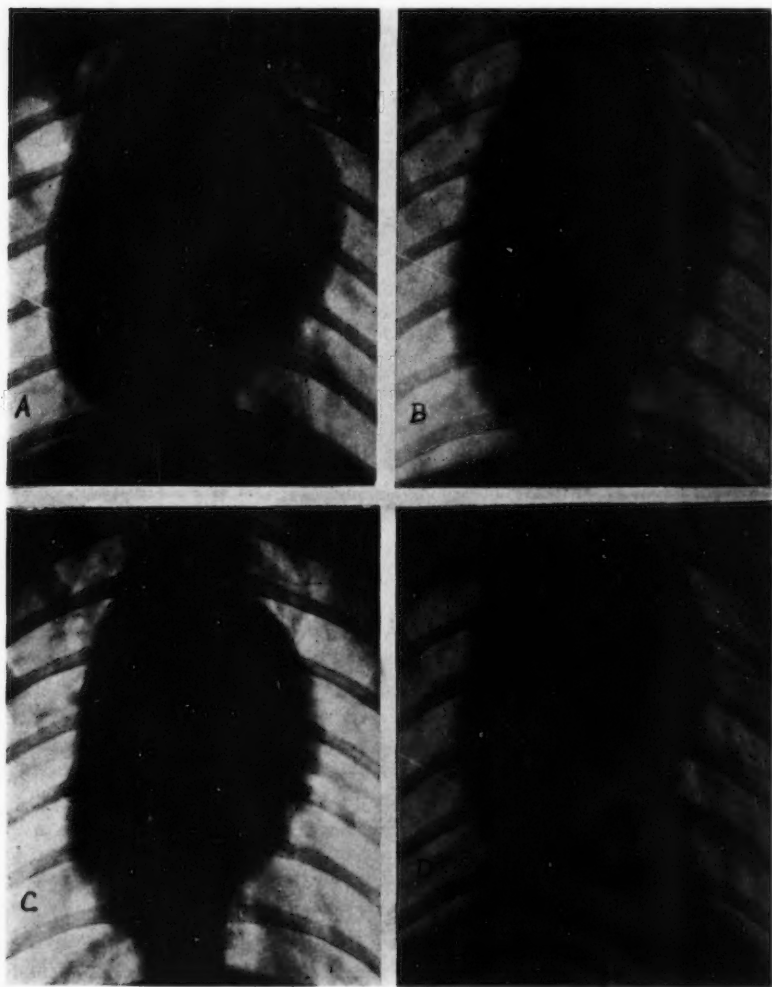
X-ray silhouettes from experiment H 60. Ether anesthesia. Rates varied by stimulation of right vagus. A, 72 beats per minute. Area = 43.4 sq. cm. B, 108 beats and area of 41.4 sq. cm. C, rate of 123 and area of 36.9 sq. cm. D, rate of 171 and area of 34.5 sq. cm.
